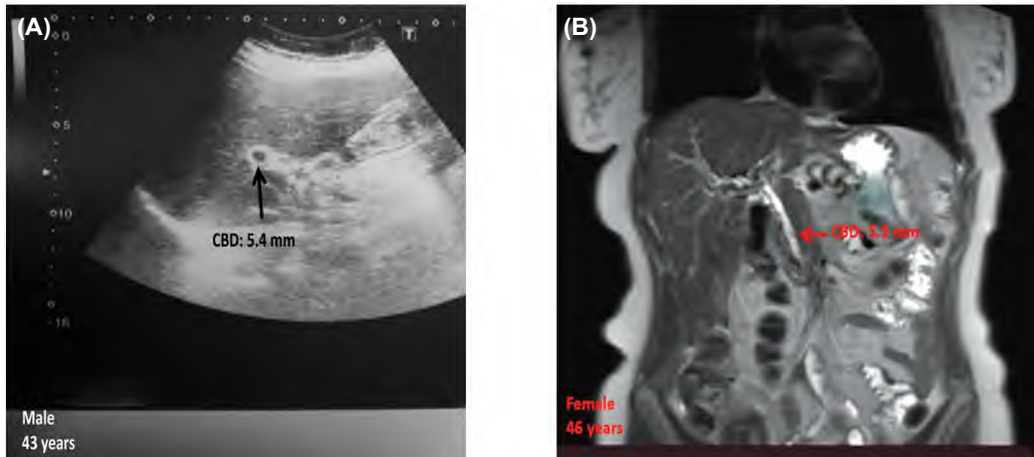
Radiological images of 2 patients of the age group of 40-50 years old with previously surgically removed GB with 5.4 ± 0.6 mm diameter of the CBD. (A) Trans abdominal ultrasound image of a 43 years old male, (B) MRI image of a 46 years old female.
